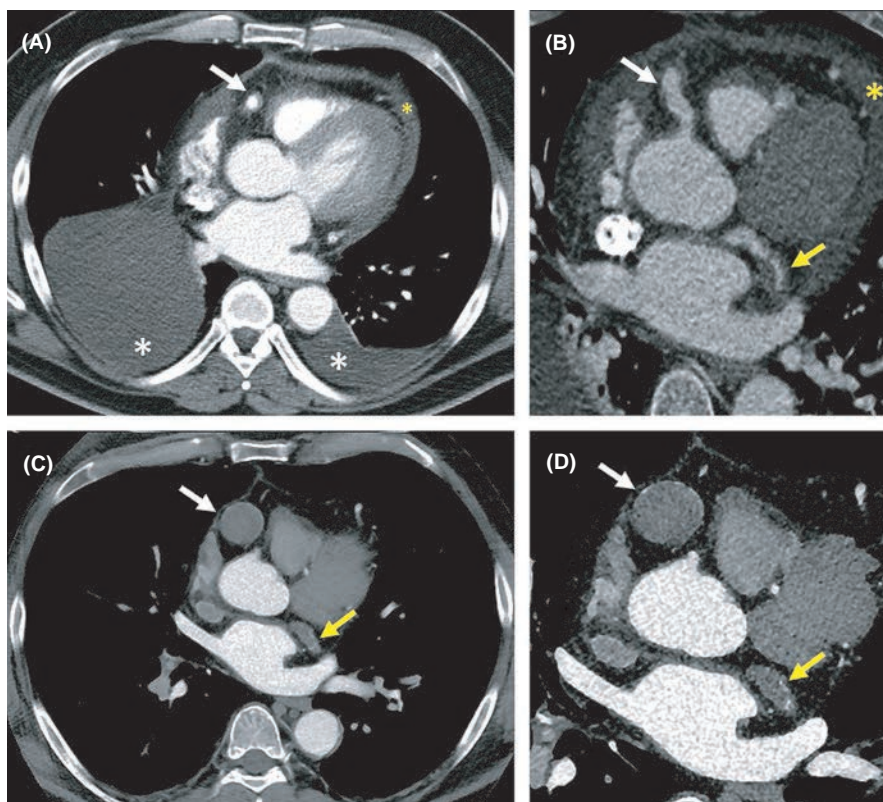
In axial post-contrast thorax computed tomography (CT) images, ectasia and diffuse wall thickening are observed in the right coronary artery (RCA) (A, white arrow). Further, there is pericardial effusion (A-B, yellow asterisk) and bilateral pleural effusion (A, white asterisks). Coronary CT angiography (CTA) image shows ectasia and diffuse wall thickening in RCA (B, white arrow) and the circumflex (Cx) artery (B, yellow arrow). Follow-up CTA images show thrombosed RCA aneurysm and occlusion of RCA (C-D, white arrow). Cx artery is also occluded (C-D, yellow arrows). Regression of pleural effusion is seen
